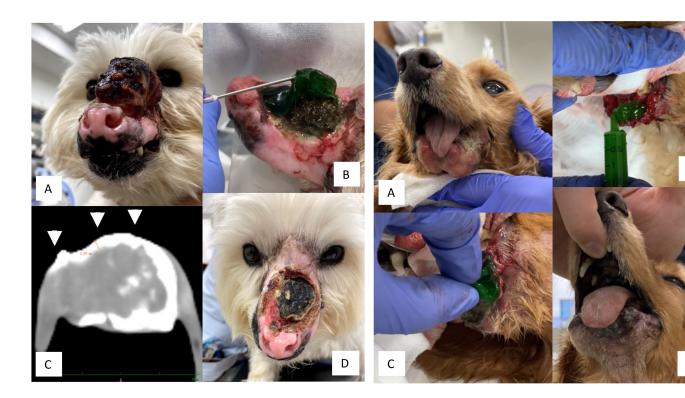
Case 2. A: Appearance at initial treatment. B: modified Mohs paste based on carboxymethyl cellulose (moM-CMC) gel was removed using a needle. C: Computed tomography (CT) scan was taken immediately after removing the moM-CMC gel. The image is shown in the transverse plane. The window level and width were 0 and 300 Hounsfield unit (HU), respectively. High CT values of zinc atoms were observed at approximately 2-mm depth from the wound surface (arrow). D: After 1 week, the malignant wound was found to be dried, and the malodor disappeared. Skin ulcer caused by the moM-CMC sol around the tumor was observed as an adverse event.
